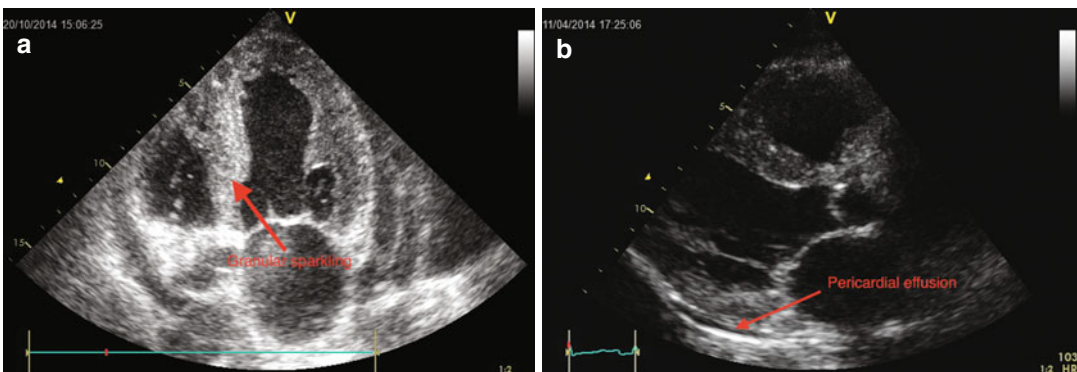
(a, b) PLAX and apical 4-CH short axis showed left ventricular hypertrophy with “granular sparkling” appearance and pericardial effusion
